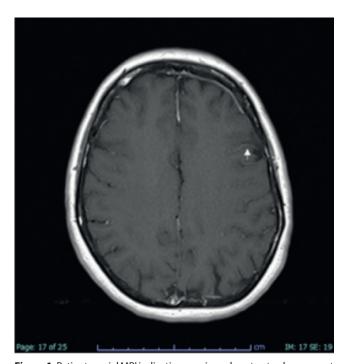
Patient cranial MRI indicating meningeal contrast enhancement (shown with an arrow)
